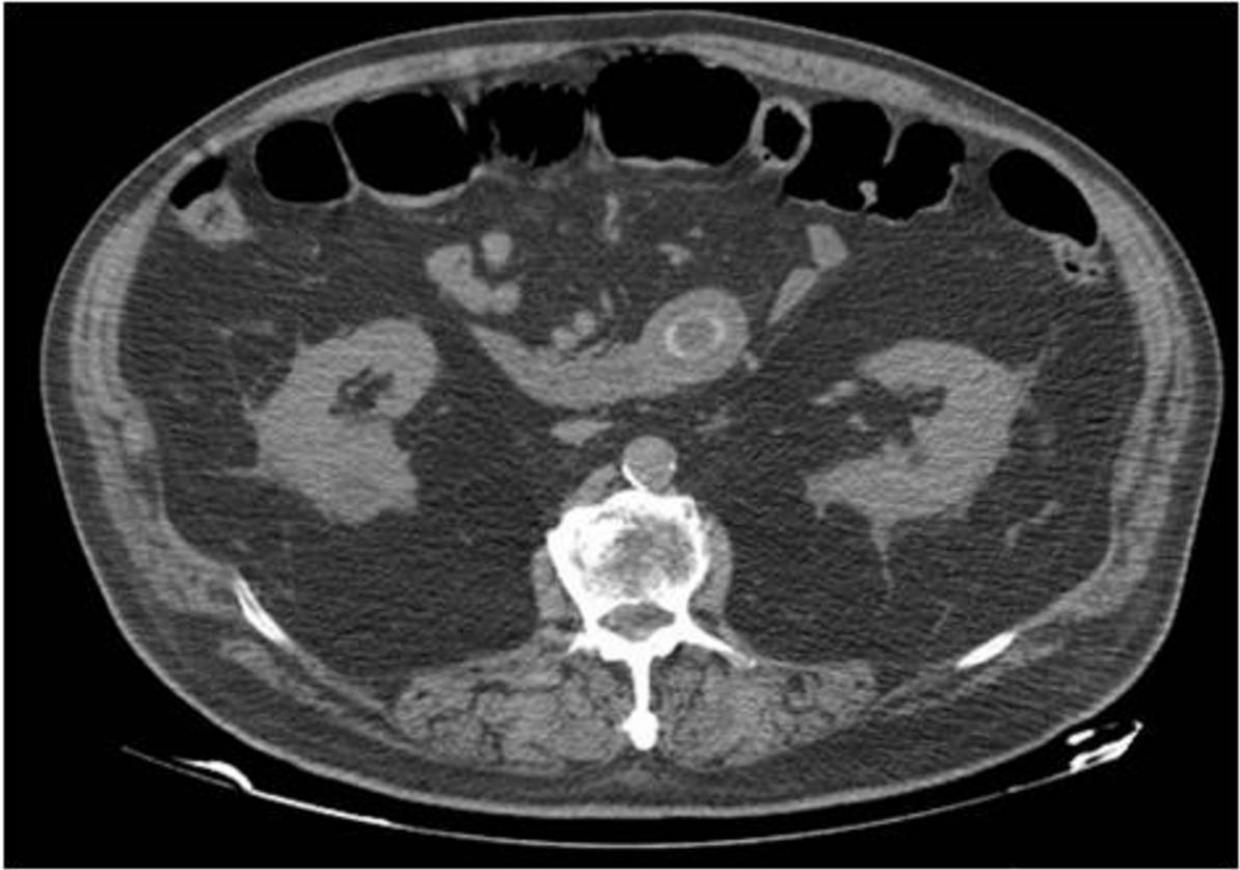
RIGLER SIGN - Abdominal CT, lung window, of a patient with a perforated sigmoid colon tumour: Air is seen outlining the inside and outside of the bowel wall - CT equivalent of the Rigler sign.
